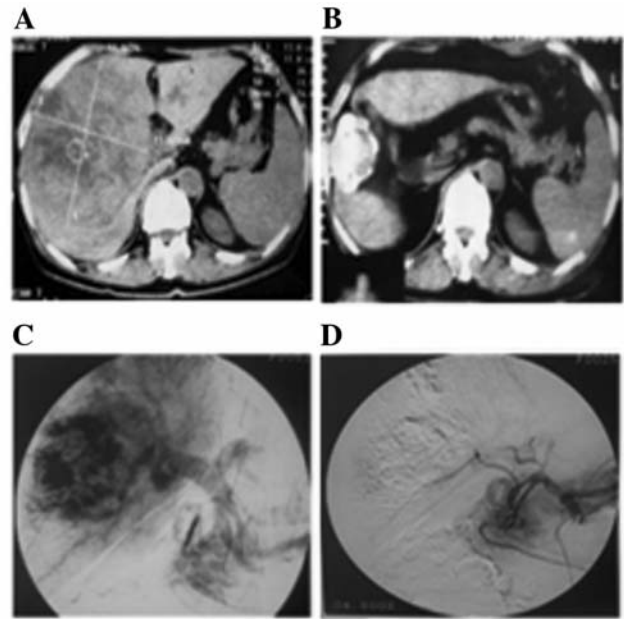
Spinal multi-slice CT scan and angiograms of a IT+MGN-3 patient. A: A multi-slice CT scan before treatment showed that the patient had a large tumor in right liver measuring $14 \times 13 \text{ cm}^2$ in plane. B: After six months of treatment the CT scan showed a decrease in tumor size to $5 \times 6 \text{ cm}^2$ in plane. C: Angiography of the same patient before treatment showed liver artery and portal angiography. D: The angiography taken just after treatment with TOCE showed that the right liver artery had complete embolization.
